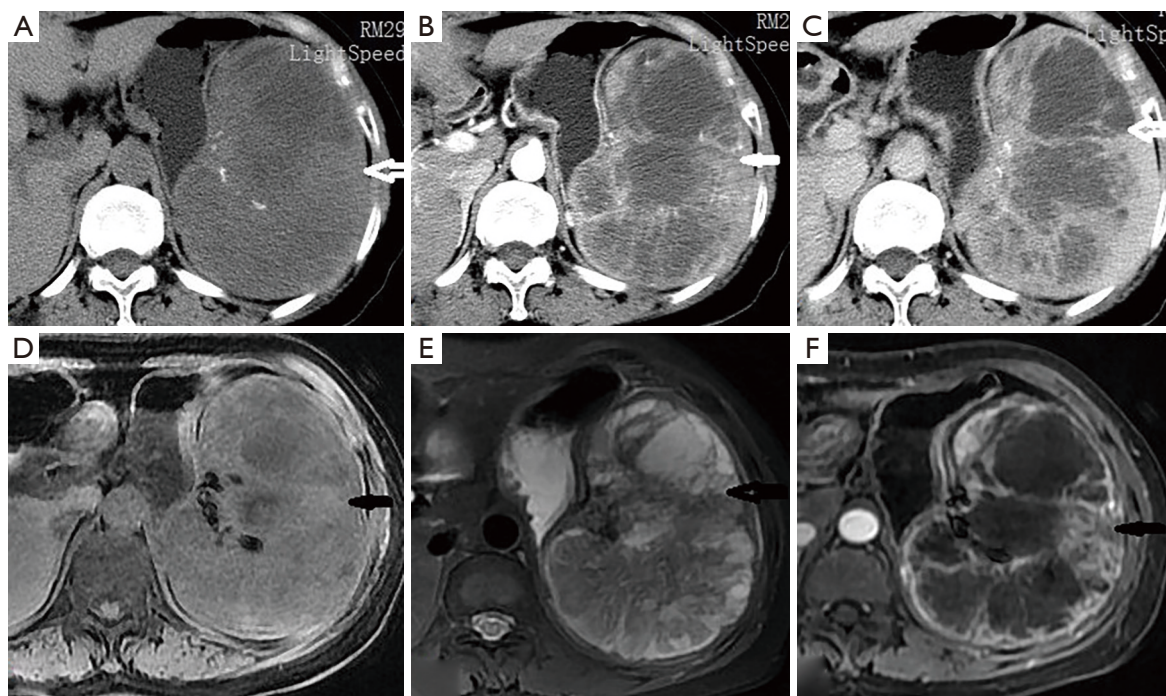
IPT-like FDCCS imaging features of spleen with extensive necrosis. (A) This case was accompanied by necrosis (the diameter of the lesion was 15 cm), the plain computed tomography (CT) scan showed that cystic lesions were more common, and there was slight calcification in low density lesions (arrow). (B,C) Contrast-enhanced CT scan showed only moderate enhancement in peripheral and septal areas, most of which were non-enhanced areas (arrows). (D,E) The lesion showed short T1 (mainly with mixed signals) and T2 (mainly with mixed signals) on magnetic resonance imaging (MRI) (arrows). (F) Contrast-enhanced MRI showed moderate enhancement of peripheral and septum, but no enhancement in most of the central areas (arrow).
